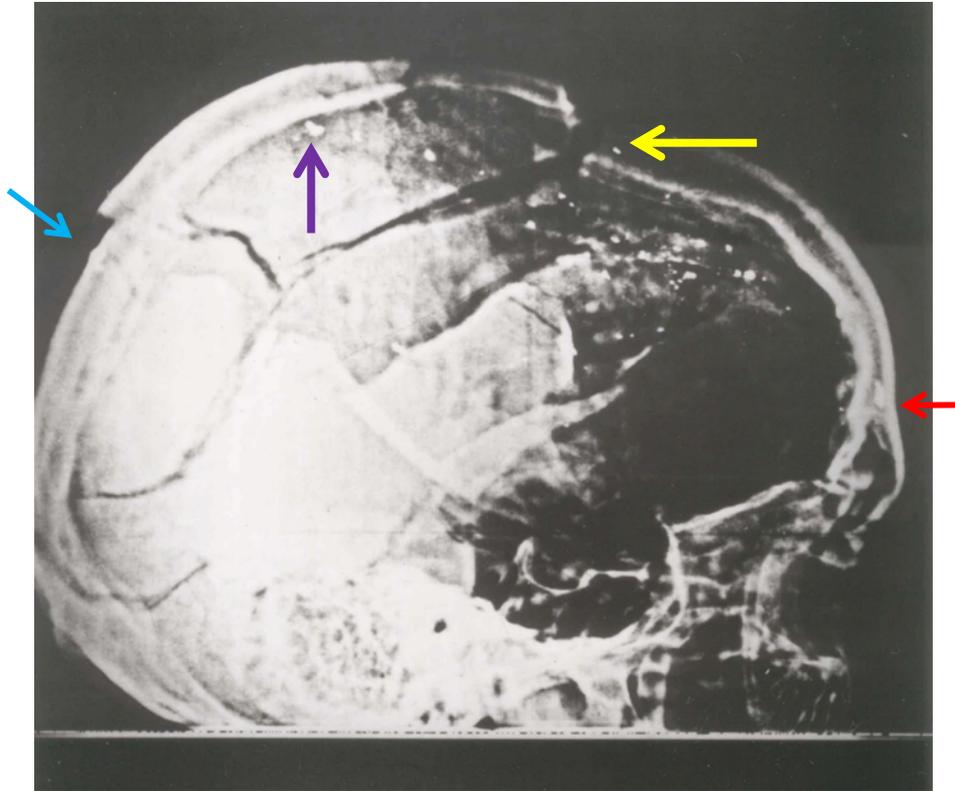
The right lateral skull X-ray. Note the faintly visible, tiny metal fragment (oblique cyan arrow), presumably the “Radiopaque Lump” of Angel and Thomas. This (authentic) fragment correlates spatially with the 6.5 mm object on the AP X-ray, but it is clearly the wrong size and optical density to match that 6.5 mm fake. The 7x2 mm authentic fragment (horizontal red arrow) lies far anterior. The yellow arrow identifies the tiny metal fragment in the left scalp. The largest fragment in the metallic trail (violet arrow) lies most posteriorly, which strongly suggests a frontal shot.
